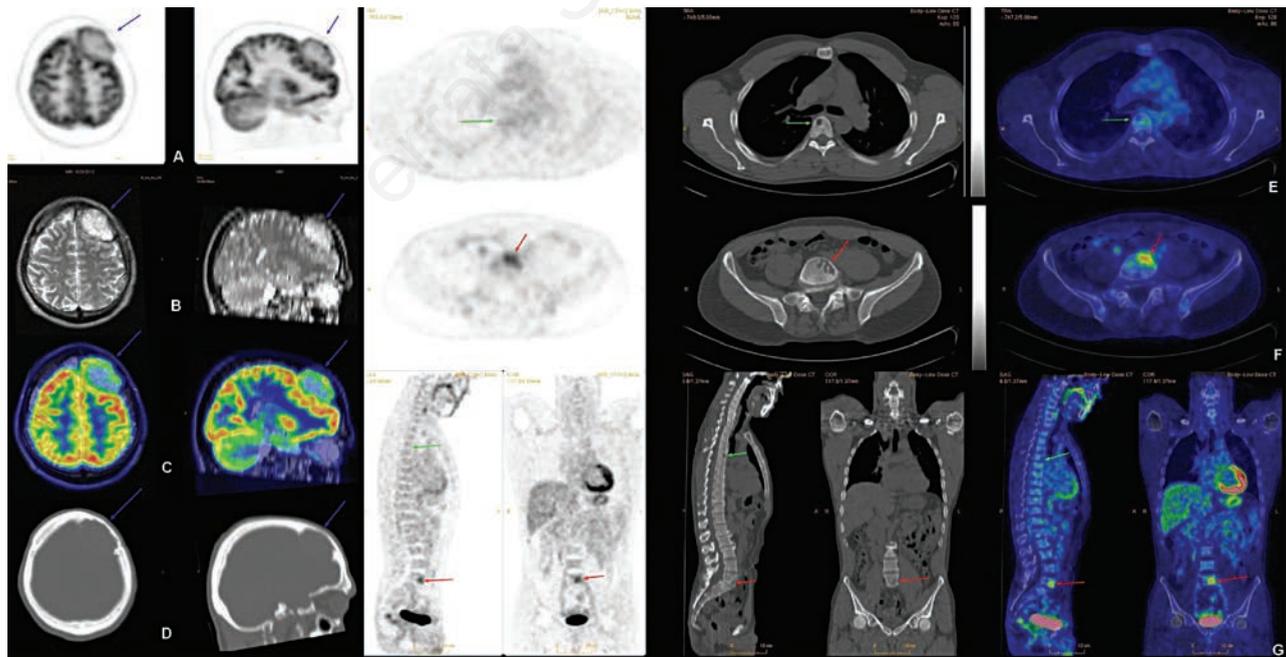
A 48-year old patient consulted for a monoclonal gammopathy. The whole body skeletal survey showed a unique extensive bone lesion in the left frontal bone of the skull and no other bone lesion was found. Bone marrow aspirate showed a plasmacytosis of 2%. On FDG PET/CT images (A: FDG PET; B: MRI; C: fused FDG PET/MRI; D: the low dose CT of the PET), the skull lesion (blue arrows) showed a high FDG uptake with a SUVmax estimated at 10.51. On the whole body FDG PET/CT images, additional lytic bone lesions were detected including one FDG-avid in the 5th lumbar vertebra (red arrows; SUVmax 3.76). The green arrows show a lytic bone lesion with no FDG uptake in the 6th dorsal vertebra.
